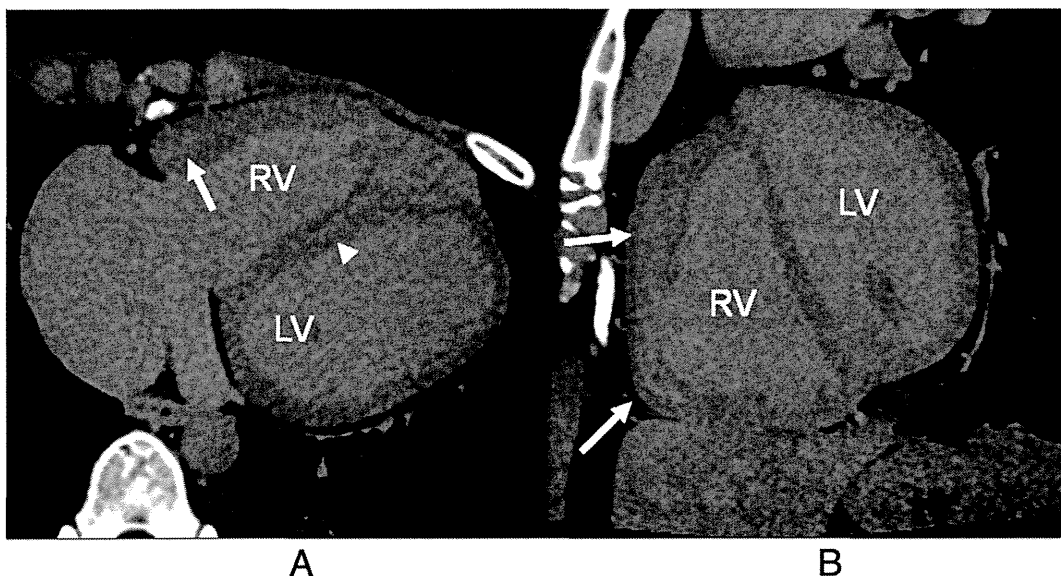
Typical imaging of myocardial fibrosis (arrows and arrow head in right ventricular (RV) myocardium) in the late phase acquisition. A: Axial source image. B: Multiplanar reconstruction image of short axis of RV. Compared with the left ventricular (LV) myocardium, hypertrophied RV myocardium showed higher computed tomography attenuation in RV anterior to inferior wall (arrows) and RV sided inter ventricular septum (arrowhead).
